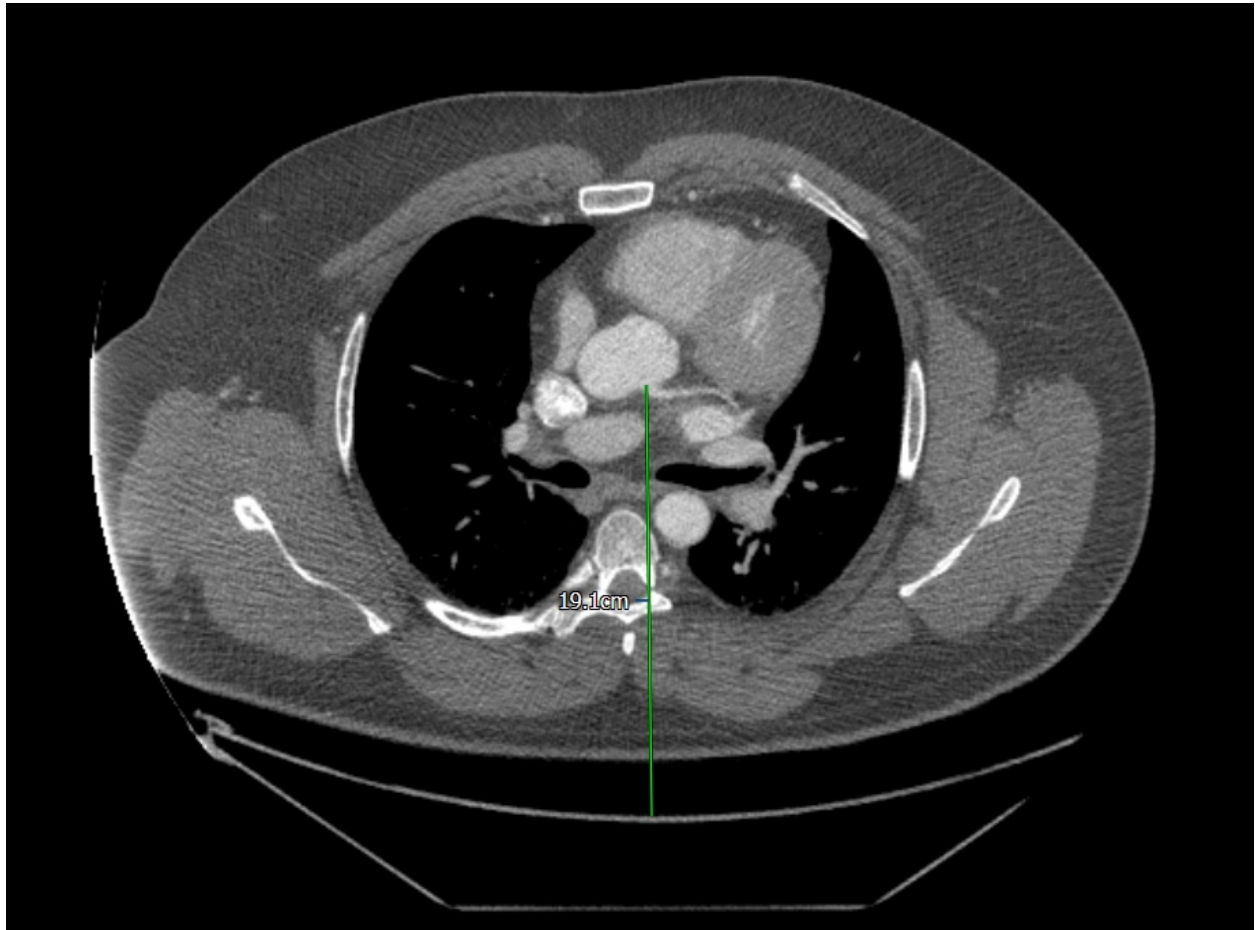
Height Measurement Using Coronary CT - demonstration of a vertical measurement between the rim of the CT table, and the left main, stem using an electronic measuring calliper. The image is a transverse section.
